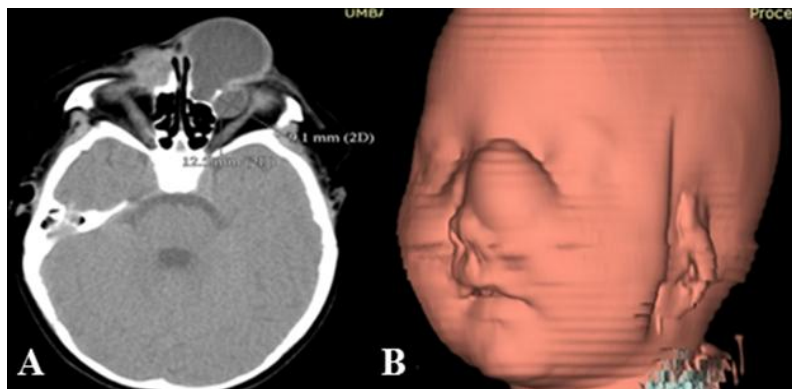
CT of frontal encephalocele: A/ axial image; B/ 3D reconstruction
